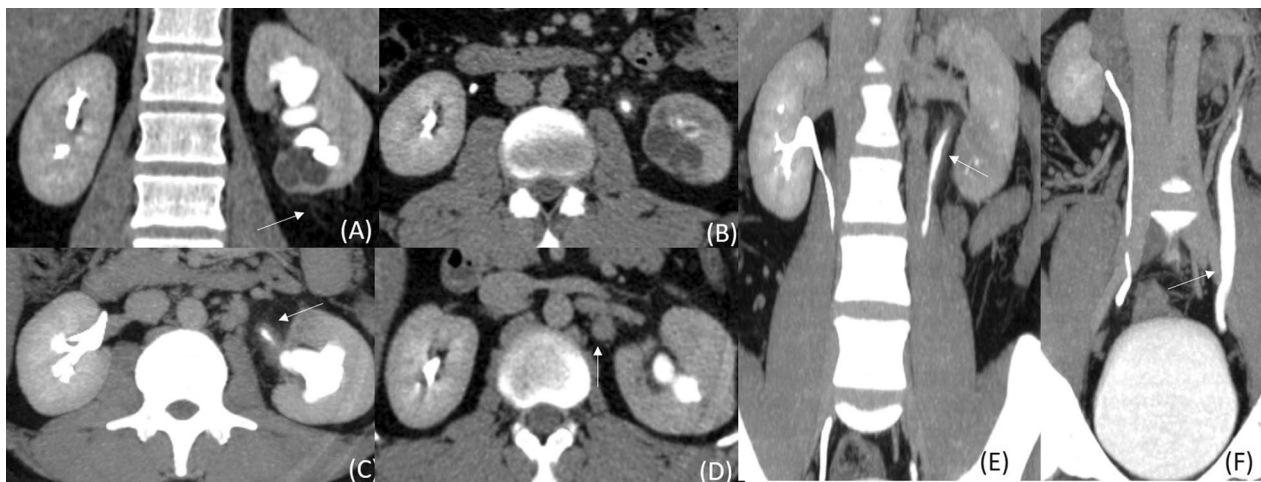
Urinary tuberculosis involving left kidney, left pelvi-ureteric junction and left ureter. CT images of a 24-year-old male show lower pole caliectasis in left kidney (A and B) with surrounding fat stranding (white arrow in A), there is thickening of pelvi-ureteric junction (white arrow in C), an enlarged perinephric lymph node with loss of fatty hilum is seen (white arrow in D) with thickening of left upper ureter (white arrow in E) and dilatation of lower ureter (white arrow in F)
